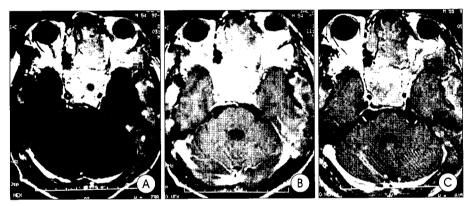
Second postoperative T1 – weighted axial enhanced magnetic resonance image shows that tumor is partially removed and the remnant tumor is visible. It still compresses optic nerve slightly(A). This means that the tumor is still growing after the chemotherapy(B). And after third operation, tumor is totally removed and there are no signs of other enhancing mass lesion(C).
